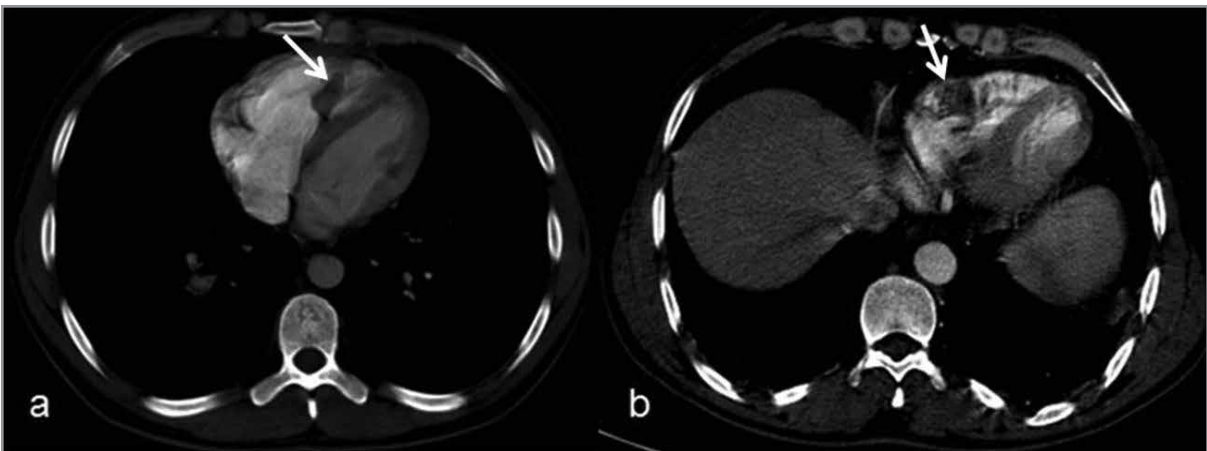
Axial pulmonary CTA slices through heart in two different patients (a and b) are displaying intracardiac filling defects in right ventricle; consistent with thrombosis (arrows).
